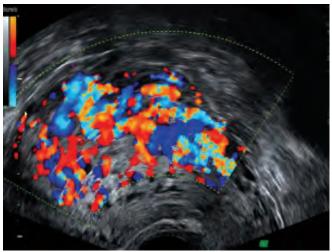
2D color-Doppler flow mapping of the tumor shown in Figure 11.20. Rich blood flow is recognized in the tumor and its lacunae *Courtesy:* U Honemeyer
